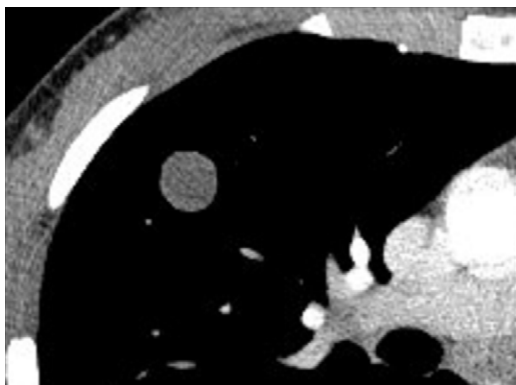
Nodule: Transverse CT image of the right upper lobe shows a round, well-defined, solid soft tissue nodule.
